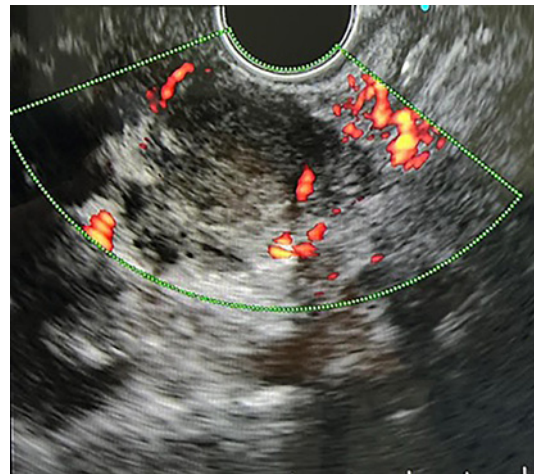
Endoscopic ultrasound showing a hypoechoic lesion with heterogeneous echo.
